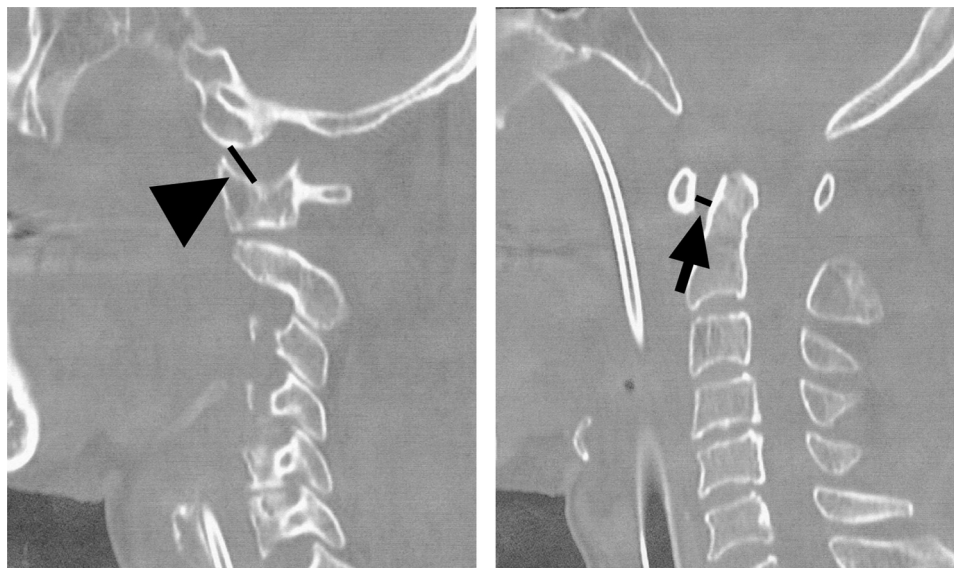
Left parasagittal (Left) and sagittal cervical spine computed tomography (Right) 12 hours after halo fixation. Condylar gap (closed arrowhead in [Left], 10 mm) and atlantodental interval (filled arrow in [Right], 5 mm) were widened again.
